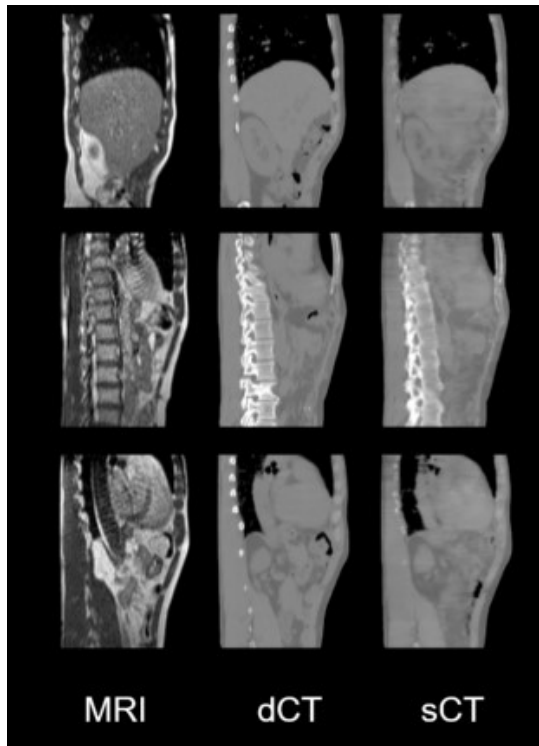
The representative sagittal slice views of MRI, dCT and sCT for abdomen
